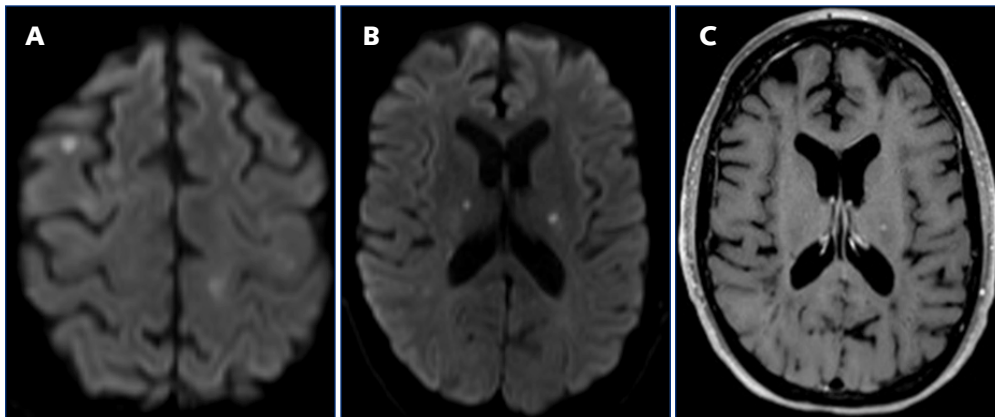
[A] Axial DWI MR imaging performed at time of presentation show multiple foci of reduced diffusivity including in the right middle frontal gyrus and [B] bilateral thalami. [C] Post-contrast Axial T2-weighted MR imaging shows punctate foci of enhancement, including a focus of enhancement which corresponds to diffusion restricting lesion in the left thalamus.
